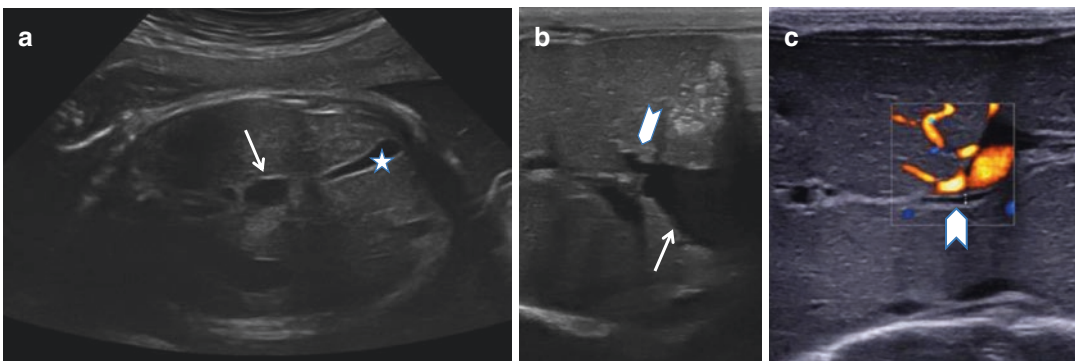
Choledochal cyst: (a) Prenatal ultrasound at 32 W GA showing the large cyst located in the liver pedicle (arrow) with a normal gallbladder (star). (b, c) Postnatal liver US shows the cyst in the hepatic pedicle that
